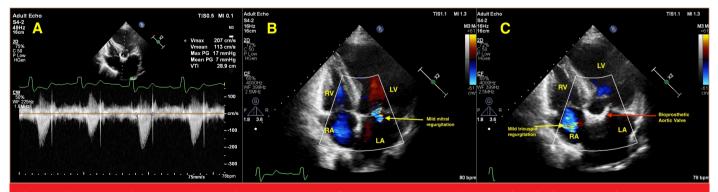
Transthoracic echocardiographic measurements after the procedure. (a) Transaortic velocity and maximum and mean gradients from apical five-chamber view, (b) Mild mitral regurgitation from apical four chamber, and (c) Mild tricuspid regurgitation from apical imaging.
